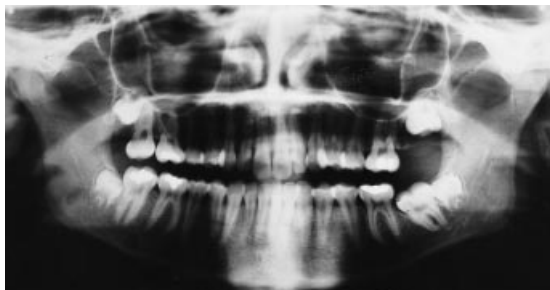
Orthopantomogram of a girl aged 15 years 1 month with arrested eruption of the lower right second molar. Taurodontism of upper left second molar is seen and a tendency to thin gracile roots generally in the dentition.
